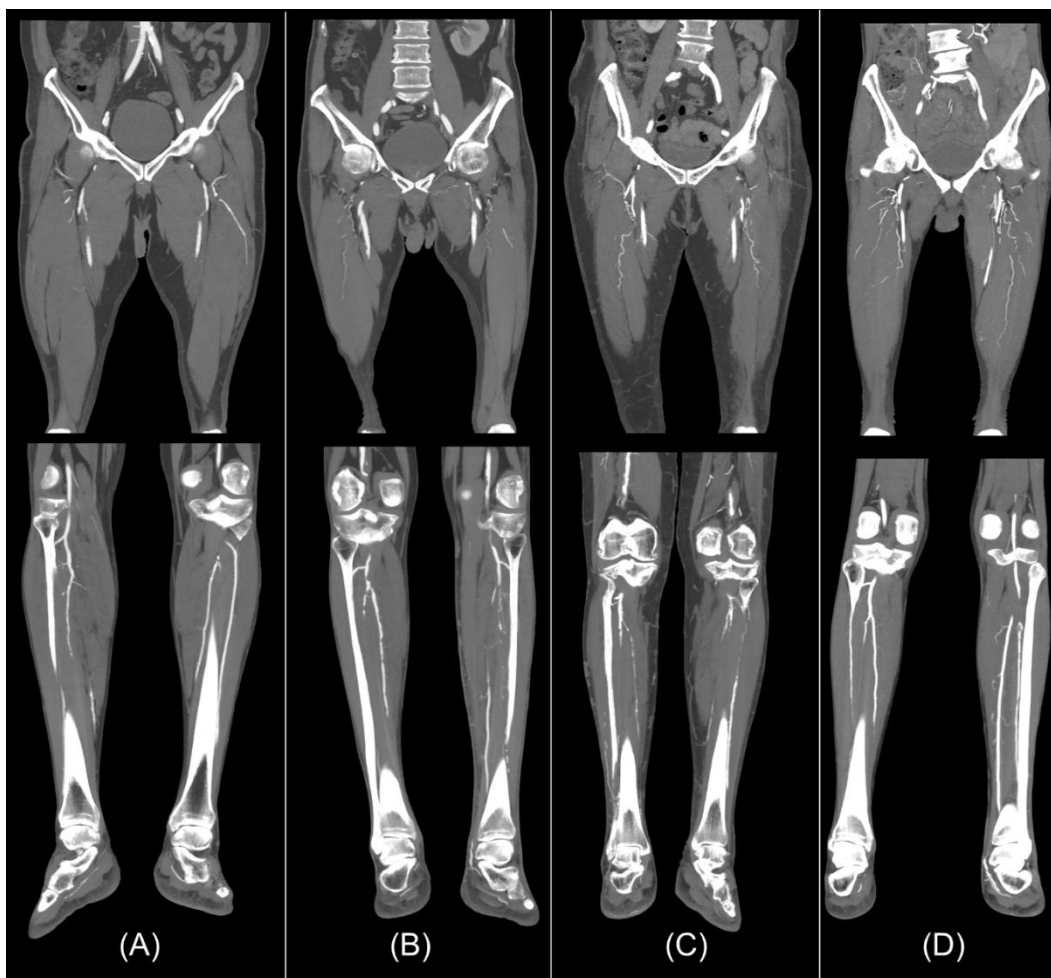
A coronal image of a lower limb vessels. CT images of a (A) 55 years old male patients scanned with protocol A, (B) 72 years old male patients scanned with protocol B, (C) 70 years old female patient scanned with protocol C, and (D) 63 years old male patient scanned with protocol D.
